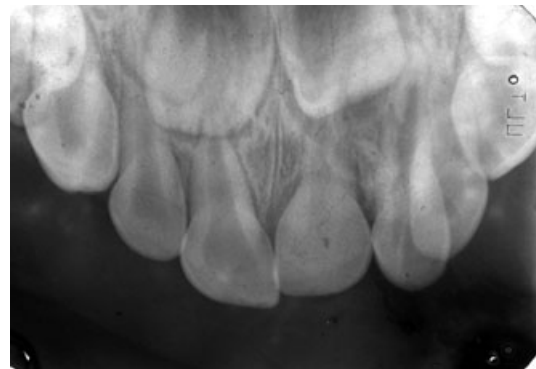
Upper occlusal radiograph showing apical displacement of the upper central incisor and primary supernumerary incisors.
